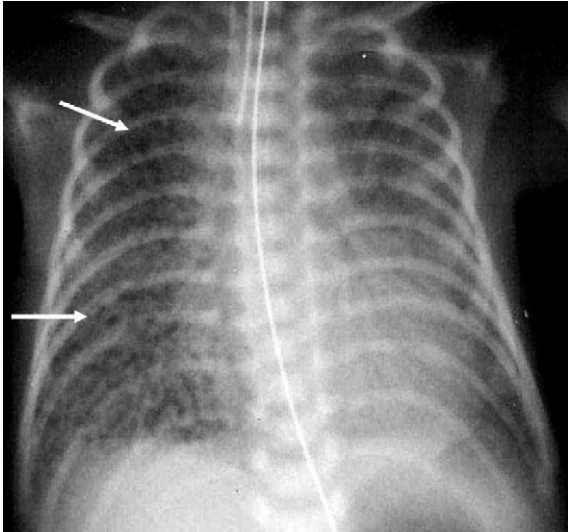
A chest radiograph of a premature infant with respiratory distress syndrome and pulmonary interstitial emphysema at the right lung field (arrows). The lung is overexpanded to the eleventh rib.
